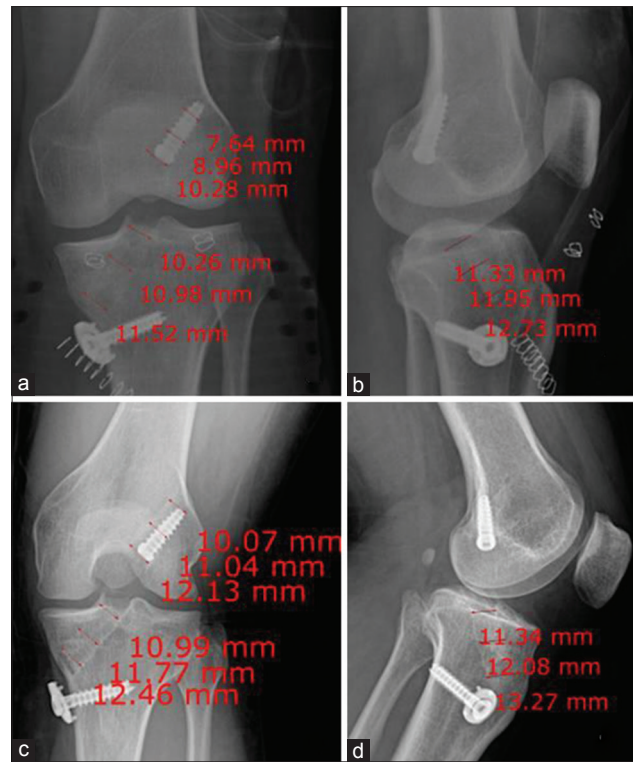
A case of femoral tunnel widening. A 29-year-old female patient underwent anterior cruciate ligament reconstruction with our surgical techniques (a) X-ray of knee joint anteroposterior view on postoperative day 1, the femoral tunnel margin was visible in the anteroposterior view and its diameters were 10.3, 9.0, and 7.6 mm (distal, middle, and proximal, respectively). (b) X-ray knee joint lateral view, the margin was not visible. (c) X-ray knee joint anteroposterior view showing nineteen months postoperatively, the femoral tunnel had increased in size to 12.1, 11.0, and 10.1 mm in the anteroposterior view (distal, middle, and proximal, respectively), and (d) X-ray knee joint lateral view showing the margin was invisible in the lateral view
